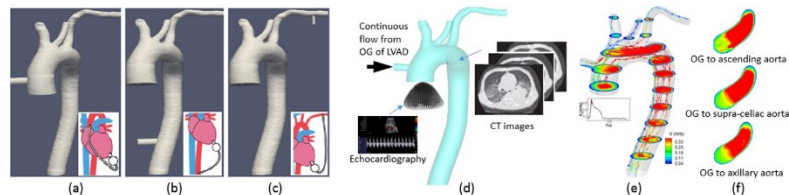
InVascular for patient-specific, noninvasive, and fast assessment to determine the optimal location of OG to: (a) ascending aorta; (b) supra-celiac aorta; and (c) axillary artery. (d) InVascular for patient-specific computational hemodynamics based on patient's CT and Echocardiography images and continuous flow from OG of LVAD. (e) Quantified velocity field (peak systole) for determining flow rate, wall-shear stress, etc. (f) Comparison of velocity contours at arch among OG to ascending aorta, supra-celiac aorta, and axillary artery.
